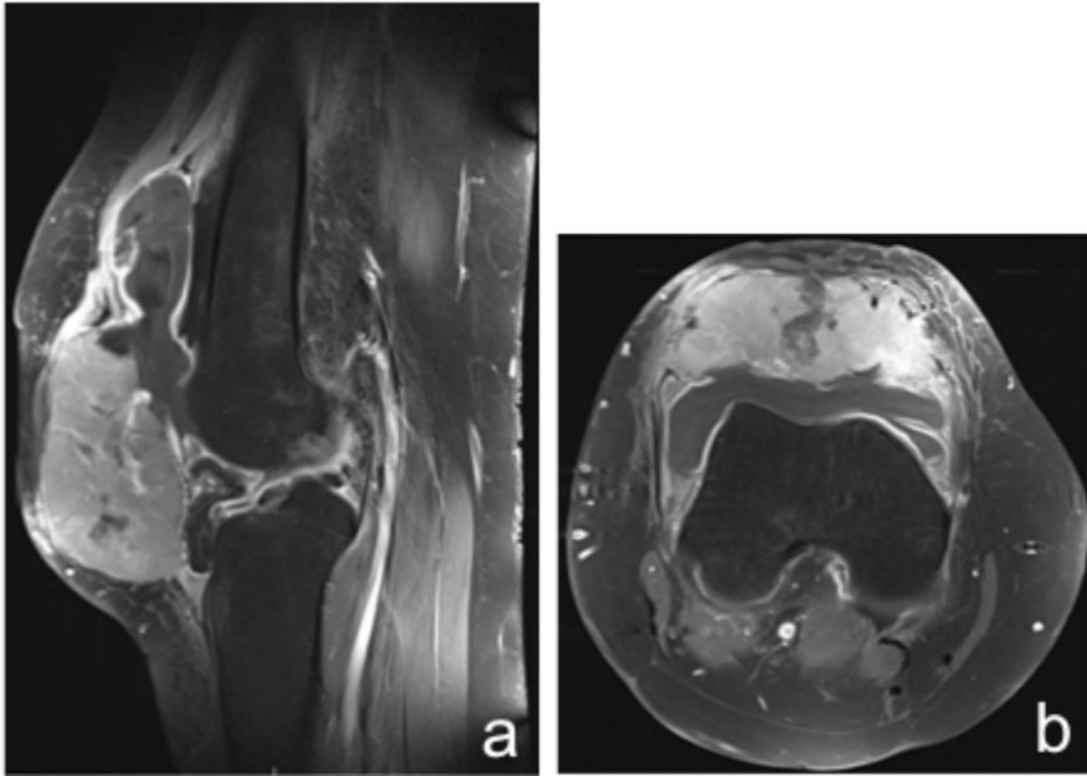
T2-weighted (a) sagittal and (b) axial magnetic resonance images of the knee demonstrating an expansile lesion replacing the patella and invading the adjacent soft tissues.
